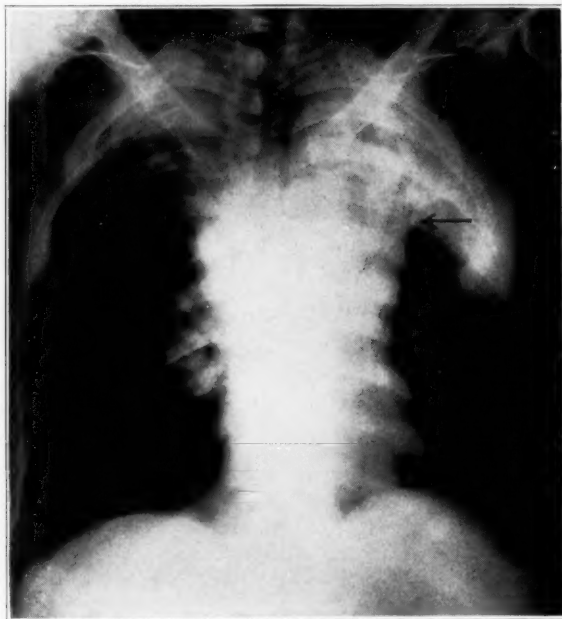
(case 15).—Roentgenogram of the chest, showing the thoracic portion of an hour-glass tumor, indicated by the arrow.
